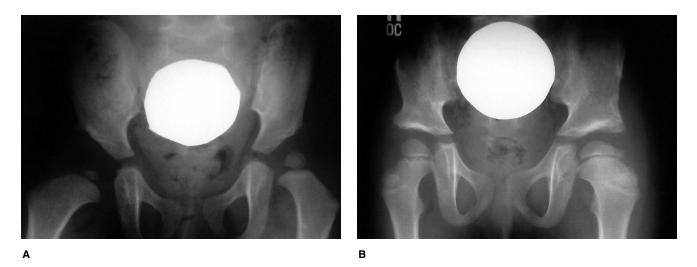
A, Preoperative radiograph of a 2-year-old girl with bilateral DDH. B, Postoperative radiograph obtained 1 year after bilateral Dega osteotomy. Both osteotomies were done at one sitting.
